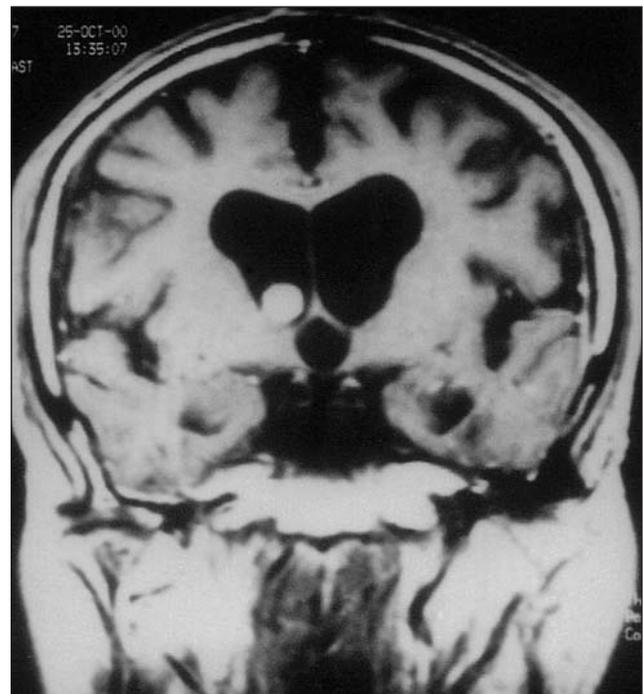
The coronal MRI scan of the patient showing a small, round, well-circumscribed mass lesion in the right lateral ventricle.
